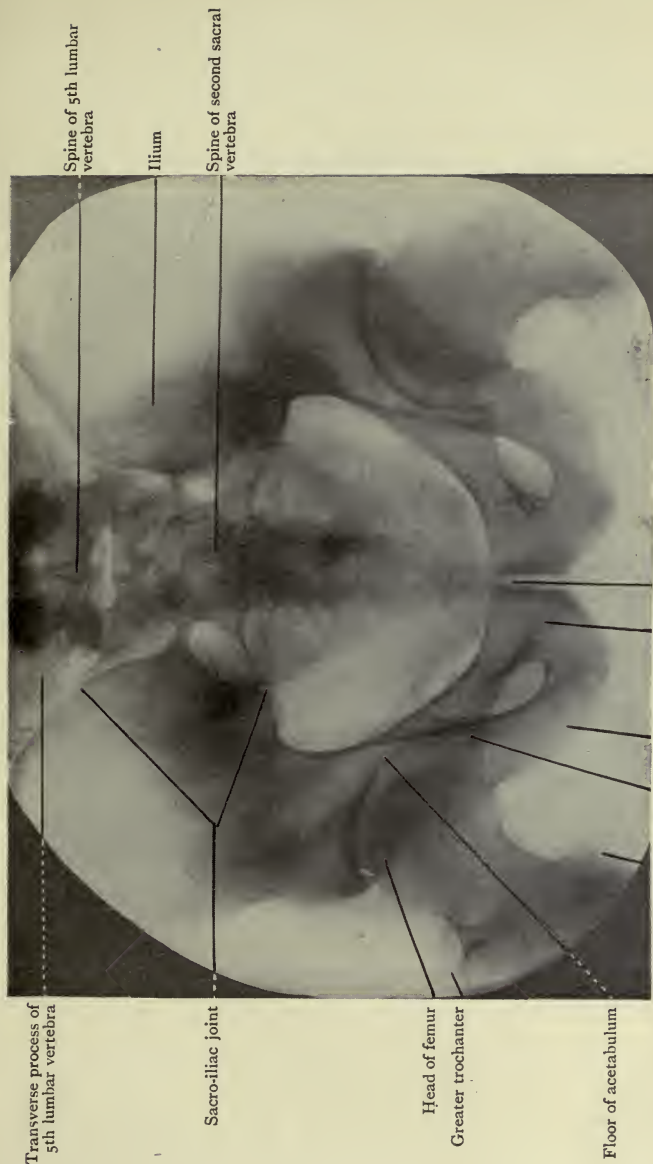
Radiograph of the Pelvis of an adult.
